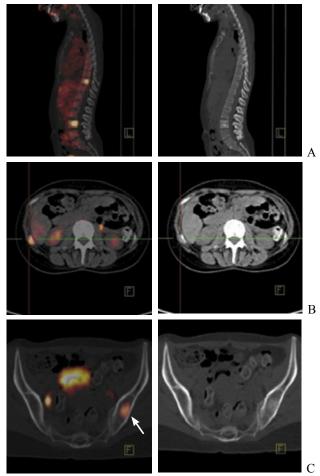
Several lesions are visualized by ¹⁸F-FDG in the spine with a SUVmax of 6.8 (A), in the twelfth right rib (B) and in the left iliac bone (C).
